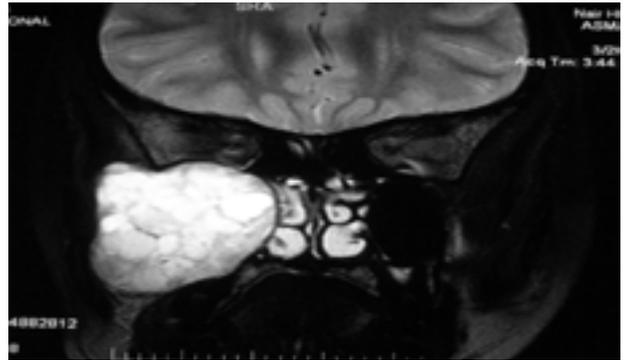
T2 weighted MRI demonstrated a low-density mass in the right infratemporal fossa and bowing in of the right maxillary sinus.
